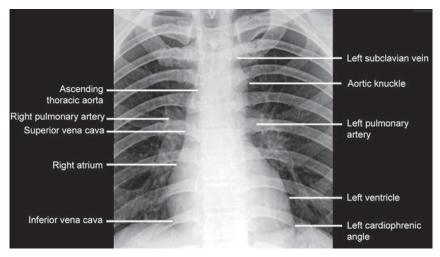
Mediastinal border on X-ray chest PA view
